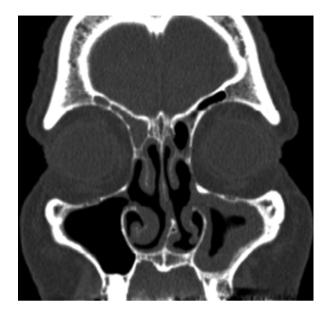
Coronal CT scan showing a lateralized right middle turbinate and neo-osteogenesis of the right frontal sinus outflow tract
